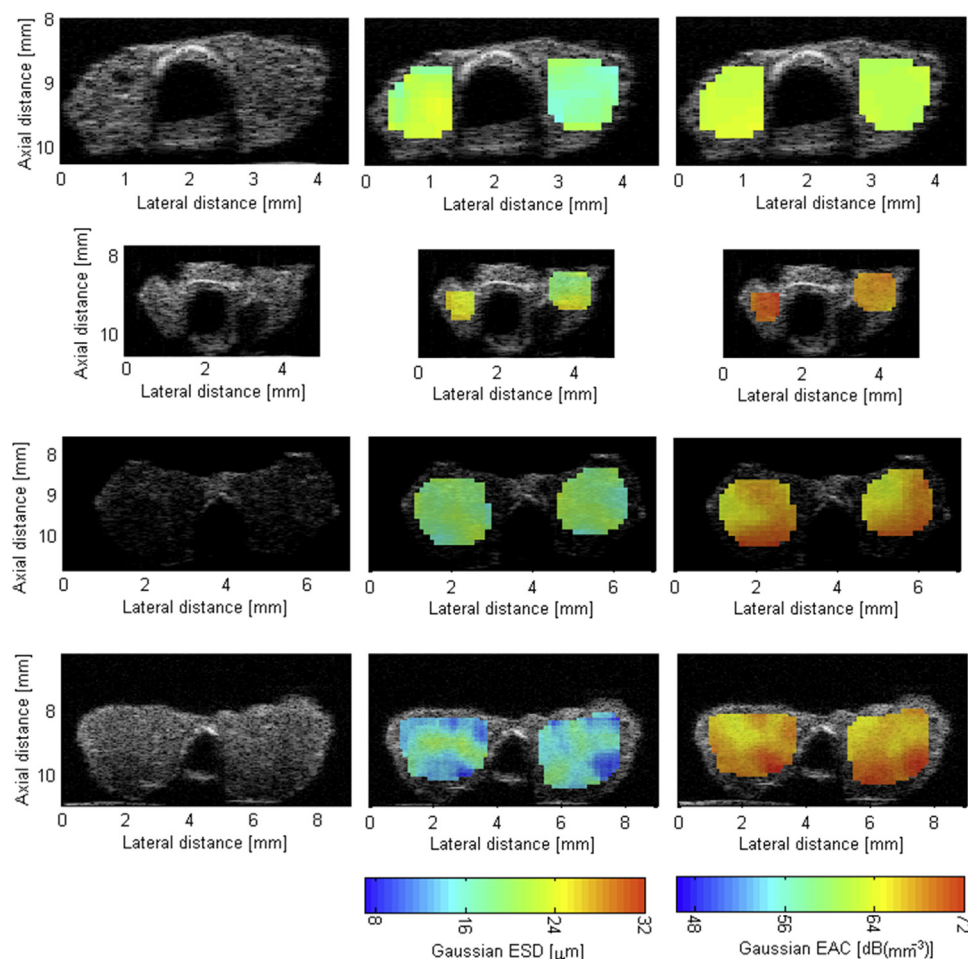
B-Mode (left column) and quantitative ultrasound images of thyroids enhanced by (middle column) effective scatterer diameter (ESD) and (right column) effective acoustic concentration (EAC). Top row: normal thyroid (no tumor observed); second row: C-cell adenoma; third row: papillary thyroid carcinoma; bottom row: follicular variant papillary thyroid carcinoma.
